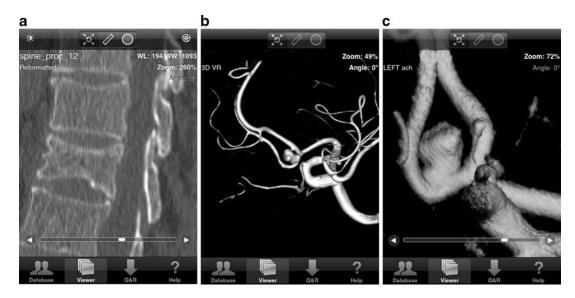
The OsiriX mobile application showing a sagittal CT of the thoracolumbar junction (a) and an MIP reformat (b) and three-dimensional volume rendering (c) (CHOUDHRI; RADVANY, 2011).
